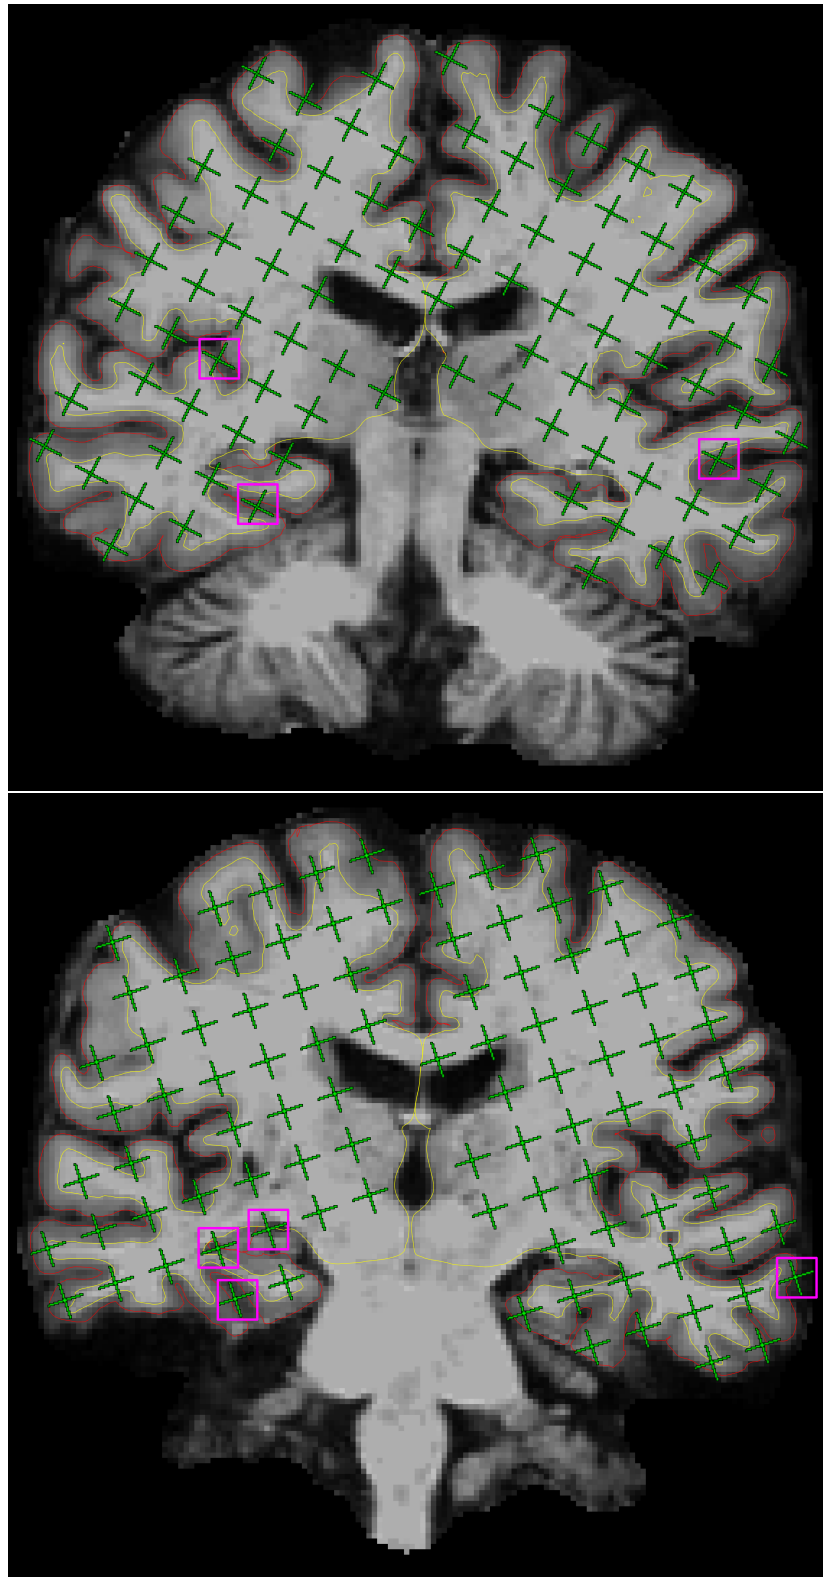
On the 8th and 9th slices of one brain MR image in the coronal view, counted test points (green) hitting the cerebrum (excluding ventricles) are overlaid onto pial profiles (red lines) segmented by `FREESURFER`. Rectangles (pink) mark the counted test points which fall outside the grey matter boundaries (red lines) and rounded rectangles (pink, racetrack-like) mark the test points hitting exactly on the grey matter boundaries.
